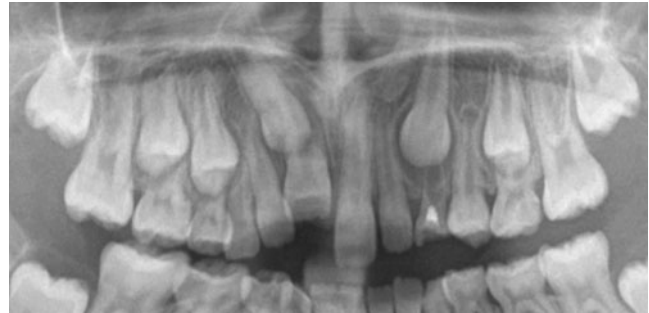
Cropped panoramic radiograph showing the ectopic position of the UR3 with loss of apical definition of the UR1
